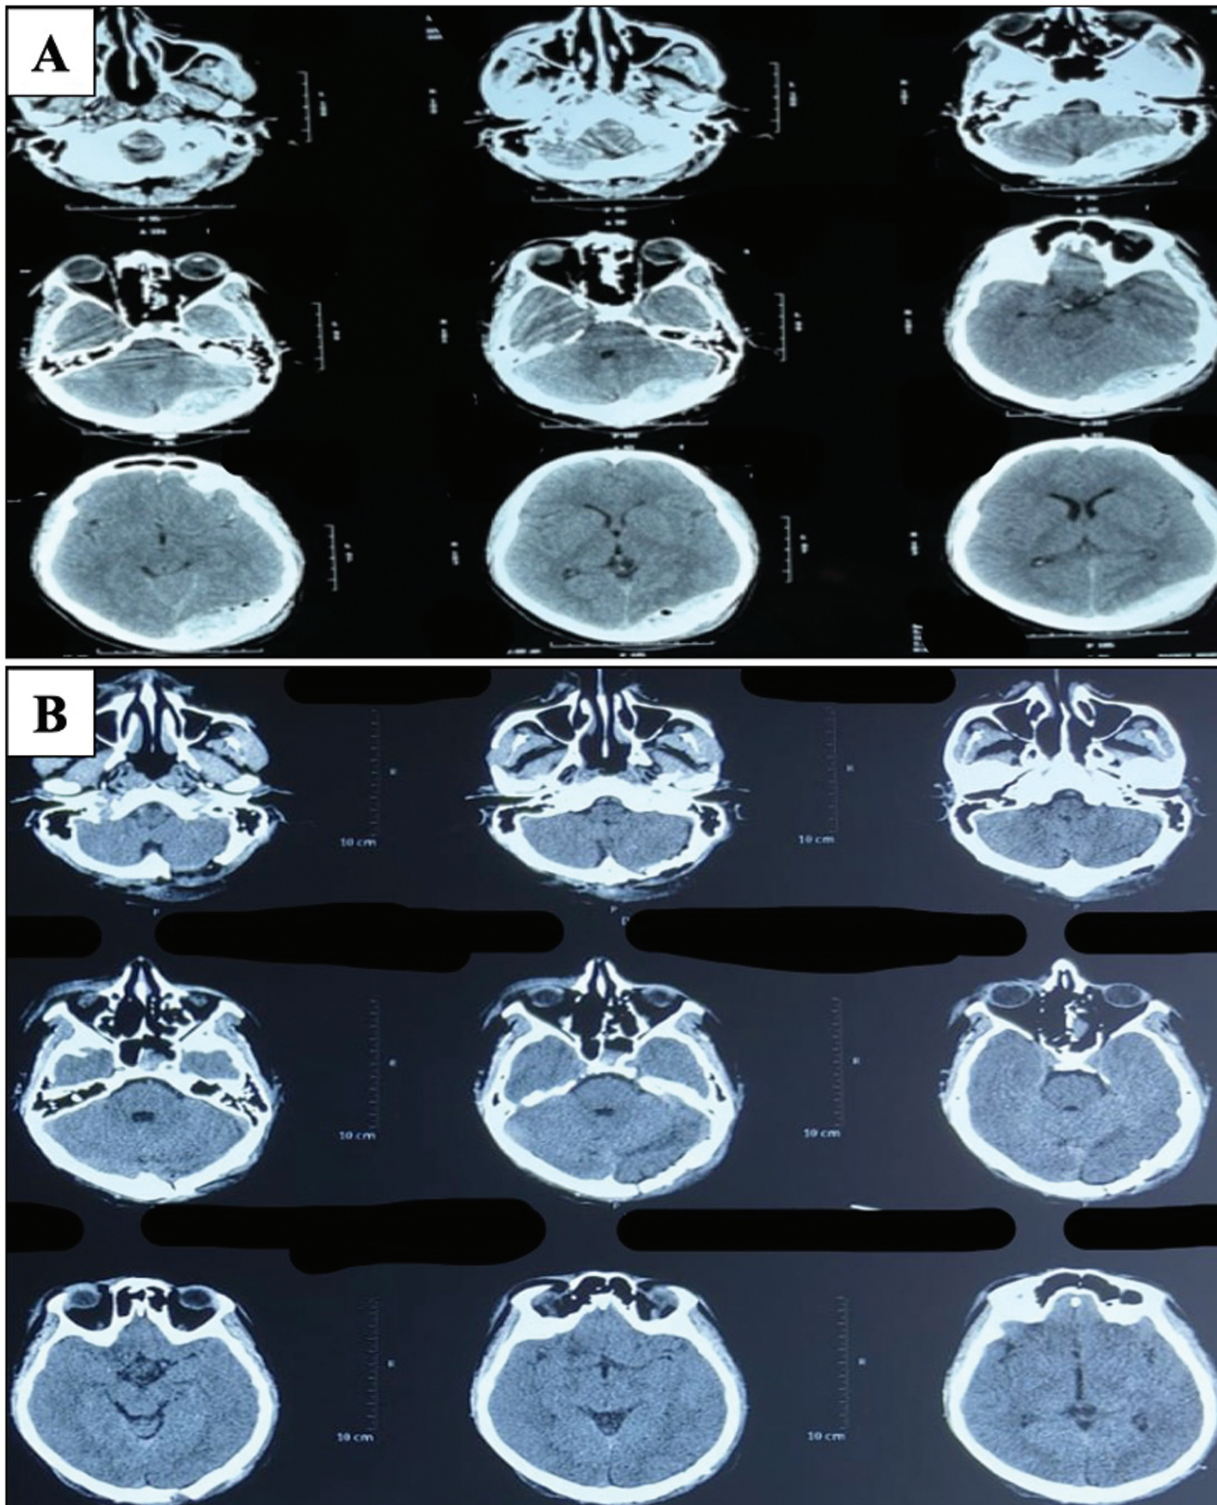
(A) Preoperative plain brain computed tomography (CT) showing left occipital and suboccipital extradural hematoma (EDH). (B) Postoperative plain CT of the brain shows the postcraniotomy status with complete evacuation of EDH.
